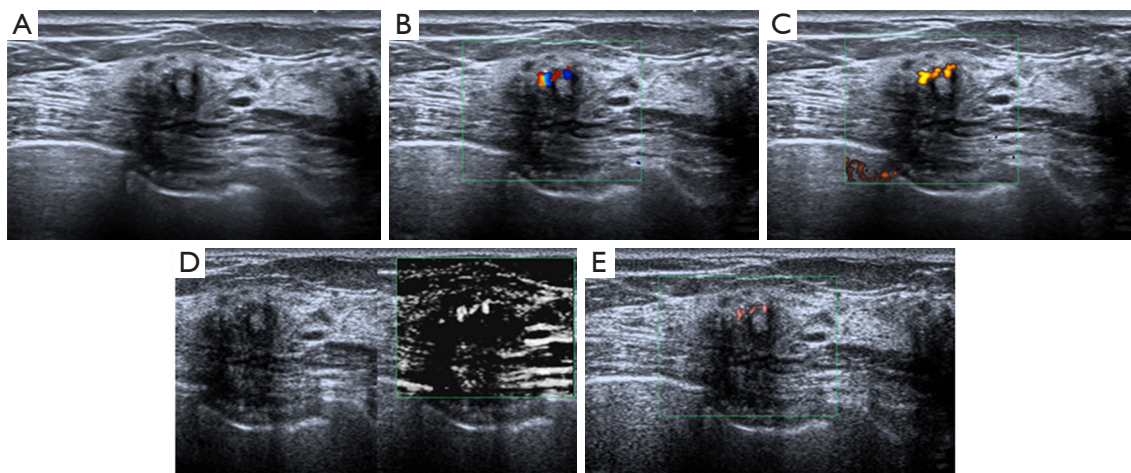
Typical grayscale US, CDFI, PDI, mSMI, and cSMI images of an invasive ductal carcinoma in the left breast of a 51-year-old patient. In the nodule, (A) grayscale US image shows a hypoechoic mass, (B) CDFI image shows 5 linear vessels with mixed distribution (total score 10, grade III), (C,E) PDI and cSMI images show >6 linear vessels with mixed distribution (total score 11, grade III), (D) mSMI image shows more detailed penetrating vessels (>6) with mixed distribution (total score 13, grade IV). US, ultrasonography; CDFI, color Doppler flow imaging; PDI, power Doppler imaging; mSMI, monochrome mode of superb microvascular imaging; cSMI, color mode of superb microvascular imaging.
